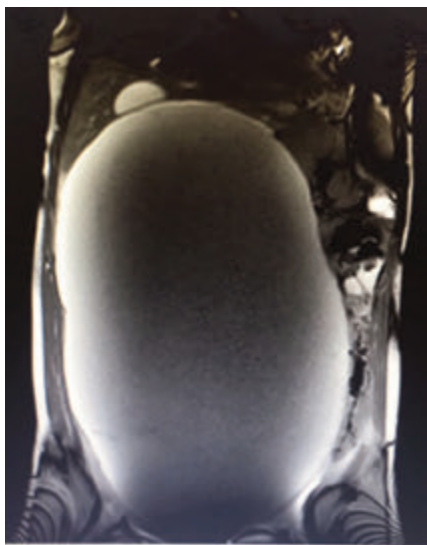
Magnetic resonance image of a giant ovarian mass (coronal view).
